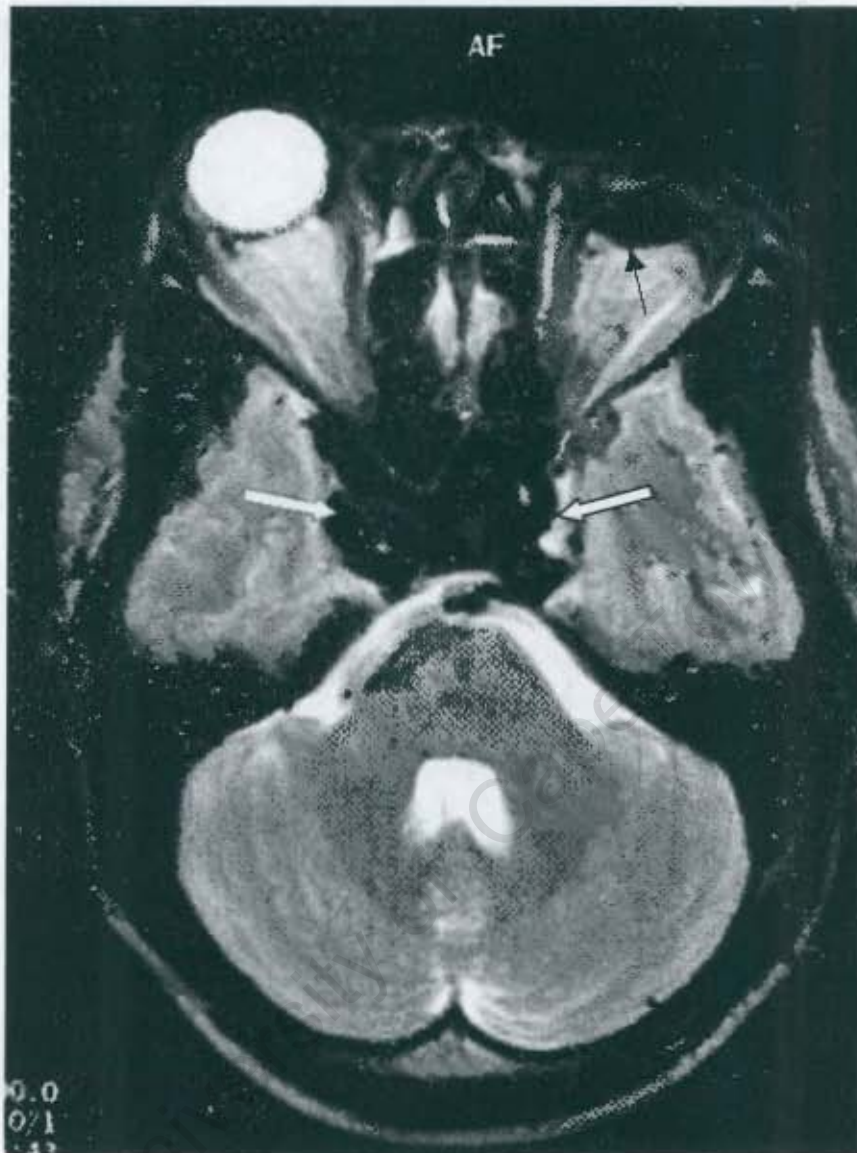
(B): Case 23. Axial T2-weighted MRI demonstrating flow voids in dilated cavernous sinuses (white arrows) consistent with a CCF. Previous left enucleation noted (single arrow).
